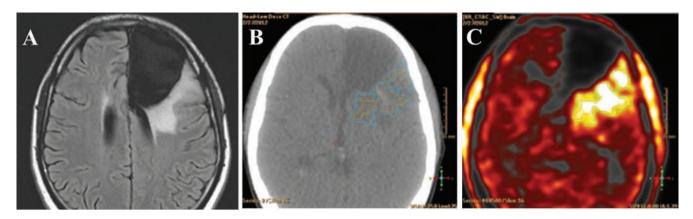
Patient after left-sided craniotomy. (A) MRI images, (B) CT images, (C) ¹⁸F-FET-PET images
